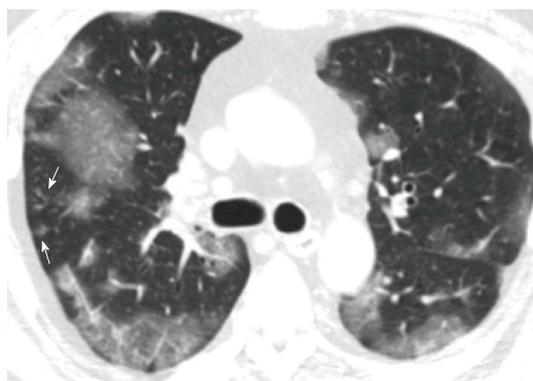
H1N1 influenza pneumonia* in a man in his 40s. Thin-section computed tomography shows patchy ground-glass opacity that are sharply demarcated from the surrounding lung parenchyma by interlobular septa (geographic distribution) in both lungs. Faint centrilobular nodules are also seen (arrow).
